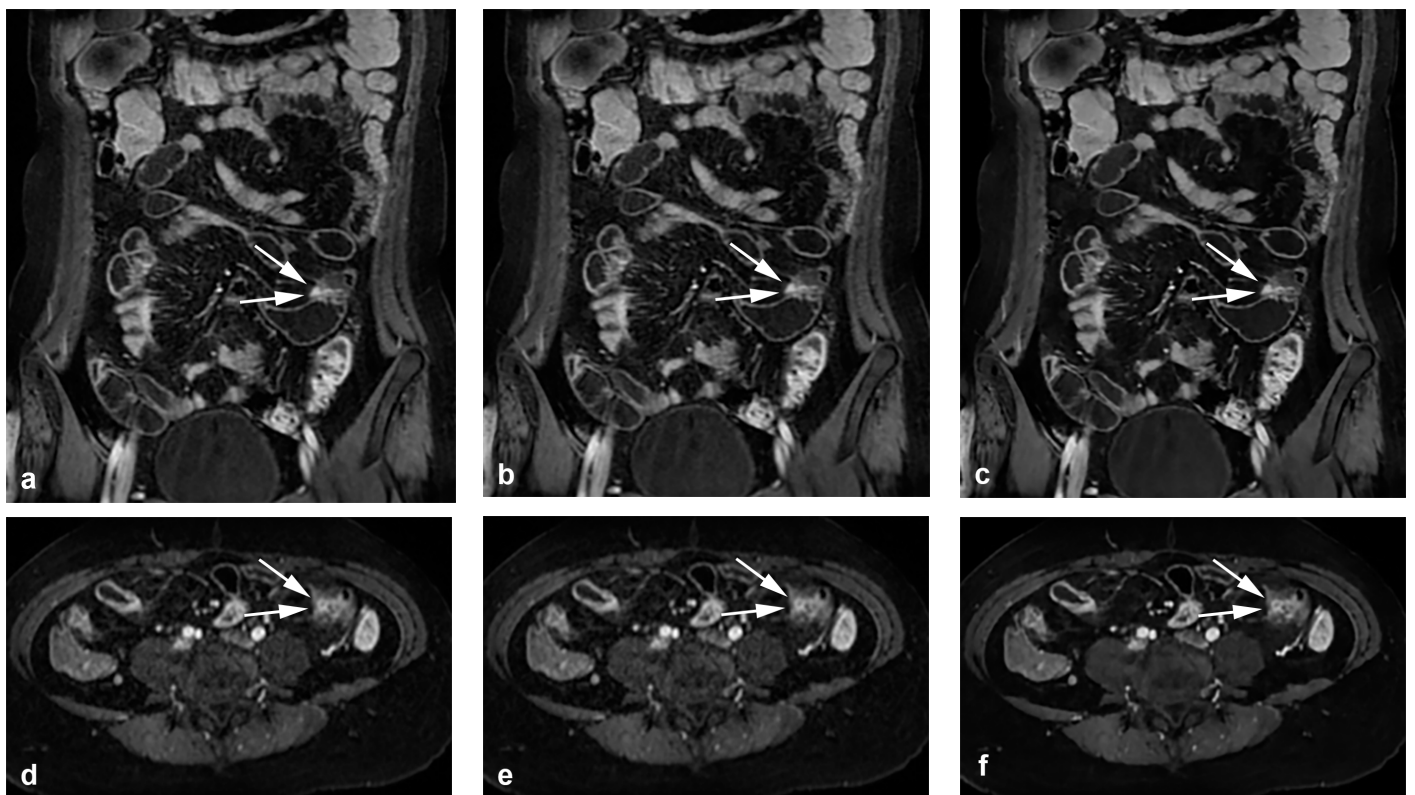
Dynamic enteric phase contrast-enhanced T1-weighted images of a 28-year-old woman with active Crohn's disease. Three sets of images were obtained, each with (a) conventional reconstruction and no image filter (original); (b) with conventional reconstruction and image filter (filtered); and (c) with deep-learning reconstruction (DLR) at the noise-reduction level of 75% (DLR). Axial images with a 1.4-mm slice thickness were reformatted from coronal images, respectively (d-f). The DLR images in both the coronal and axial planes (c,f) show lower noise, a sharper margin of the bowel wall and vasculature, and better contrast of bowel wall stratification than the other two images (a, b, d, e). In the coronal image sets, a small sinus tract is detected in the proximal ileum (arrows), which is better visualized in the DLR image (c). The corresponding penetrating lesion in the proximal ileum is also well visualized in the sets of axial images (arrows) and is most clearly visible in DLR (f), which helps increase diagnostic confidence.
